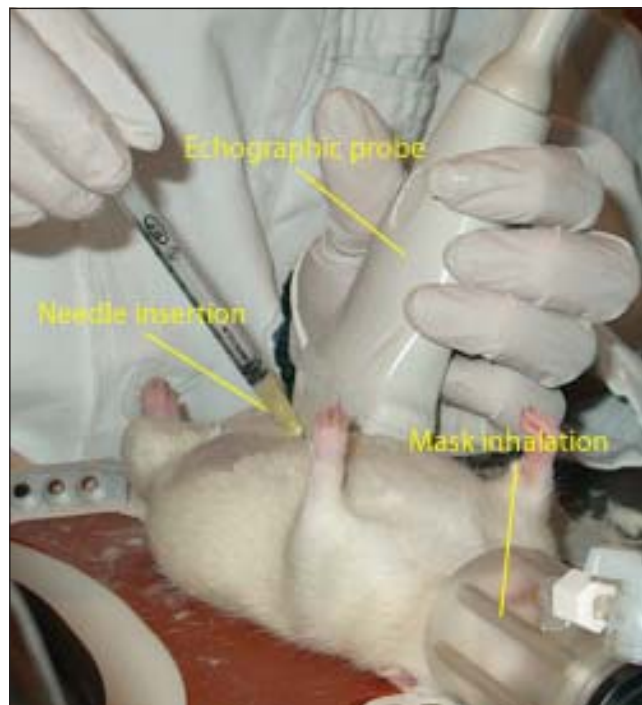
Setup for collecting amniotic fluid by the ultrasound-guided technique.
